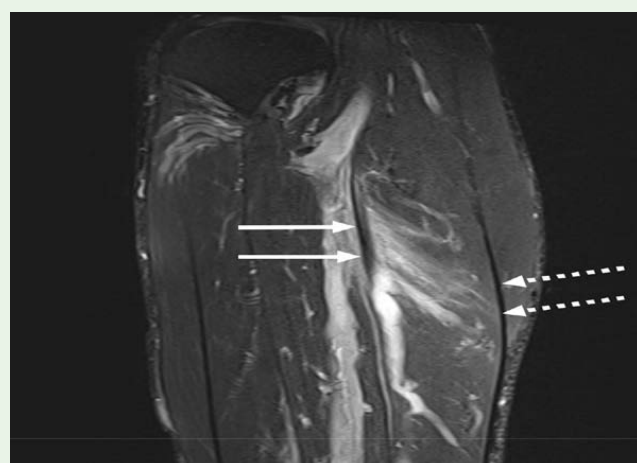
Sagittal T2-FS MRI of the left calf showing thick scarring of the intra-muscular aponeurosis (arrows) and associated recurrent muscle strain with feathery high T2 signal extending obliquely along the muscle fascicles to the functionally adjacent and thickened soleus aponeurosis (dotted arrow).
